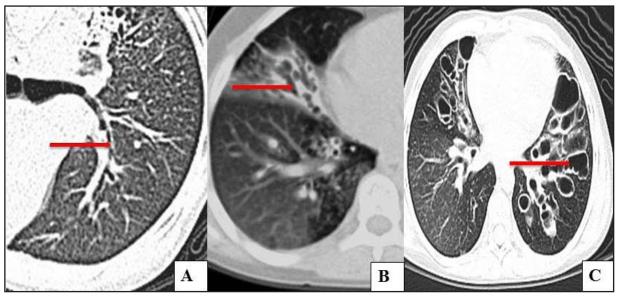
Stages of bronchiectasis according to the Reid classification system. High-resolution computed tomography views of different stages of bronchiectasis with arrows indicating the abnormalities: A: cylindrical bronchiectasis; B: varicose bronchiectasis; C: saccular bronchiectasis.
